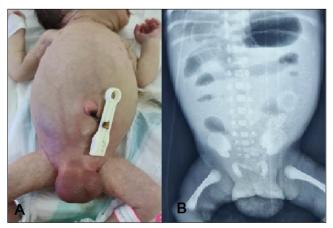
A) Neonate with Aphallia and abdominal distension. B) X-ray showing multiple air-fluid levels.
